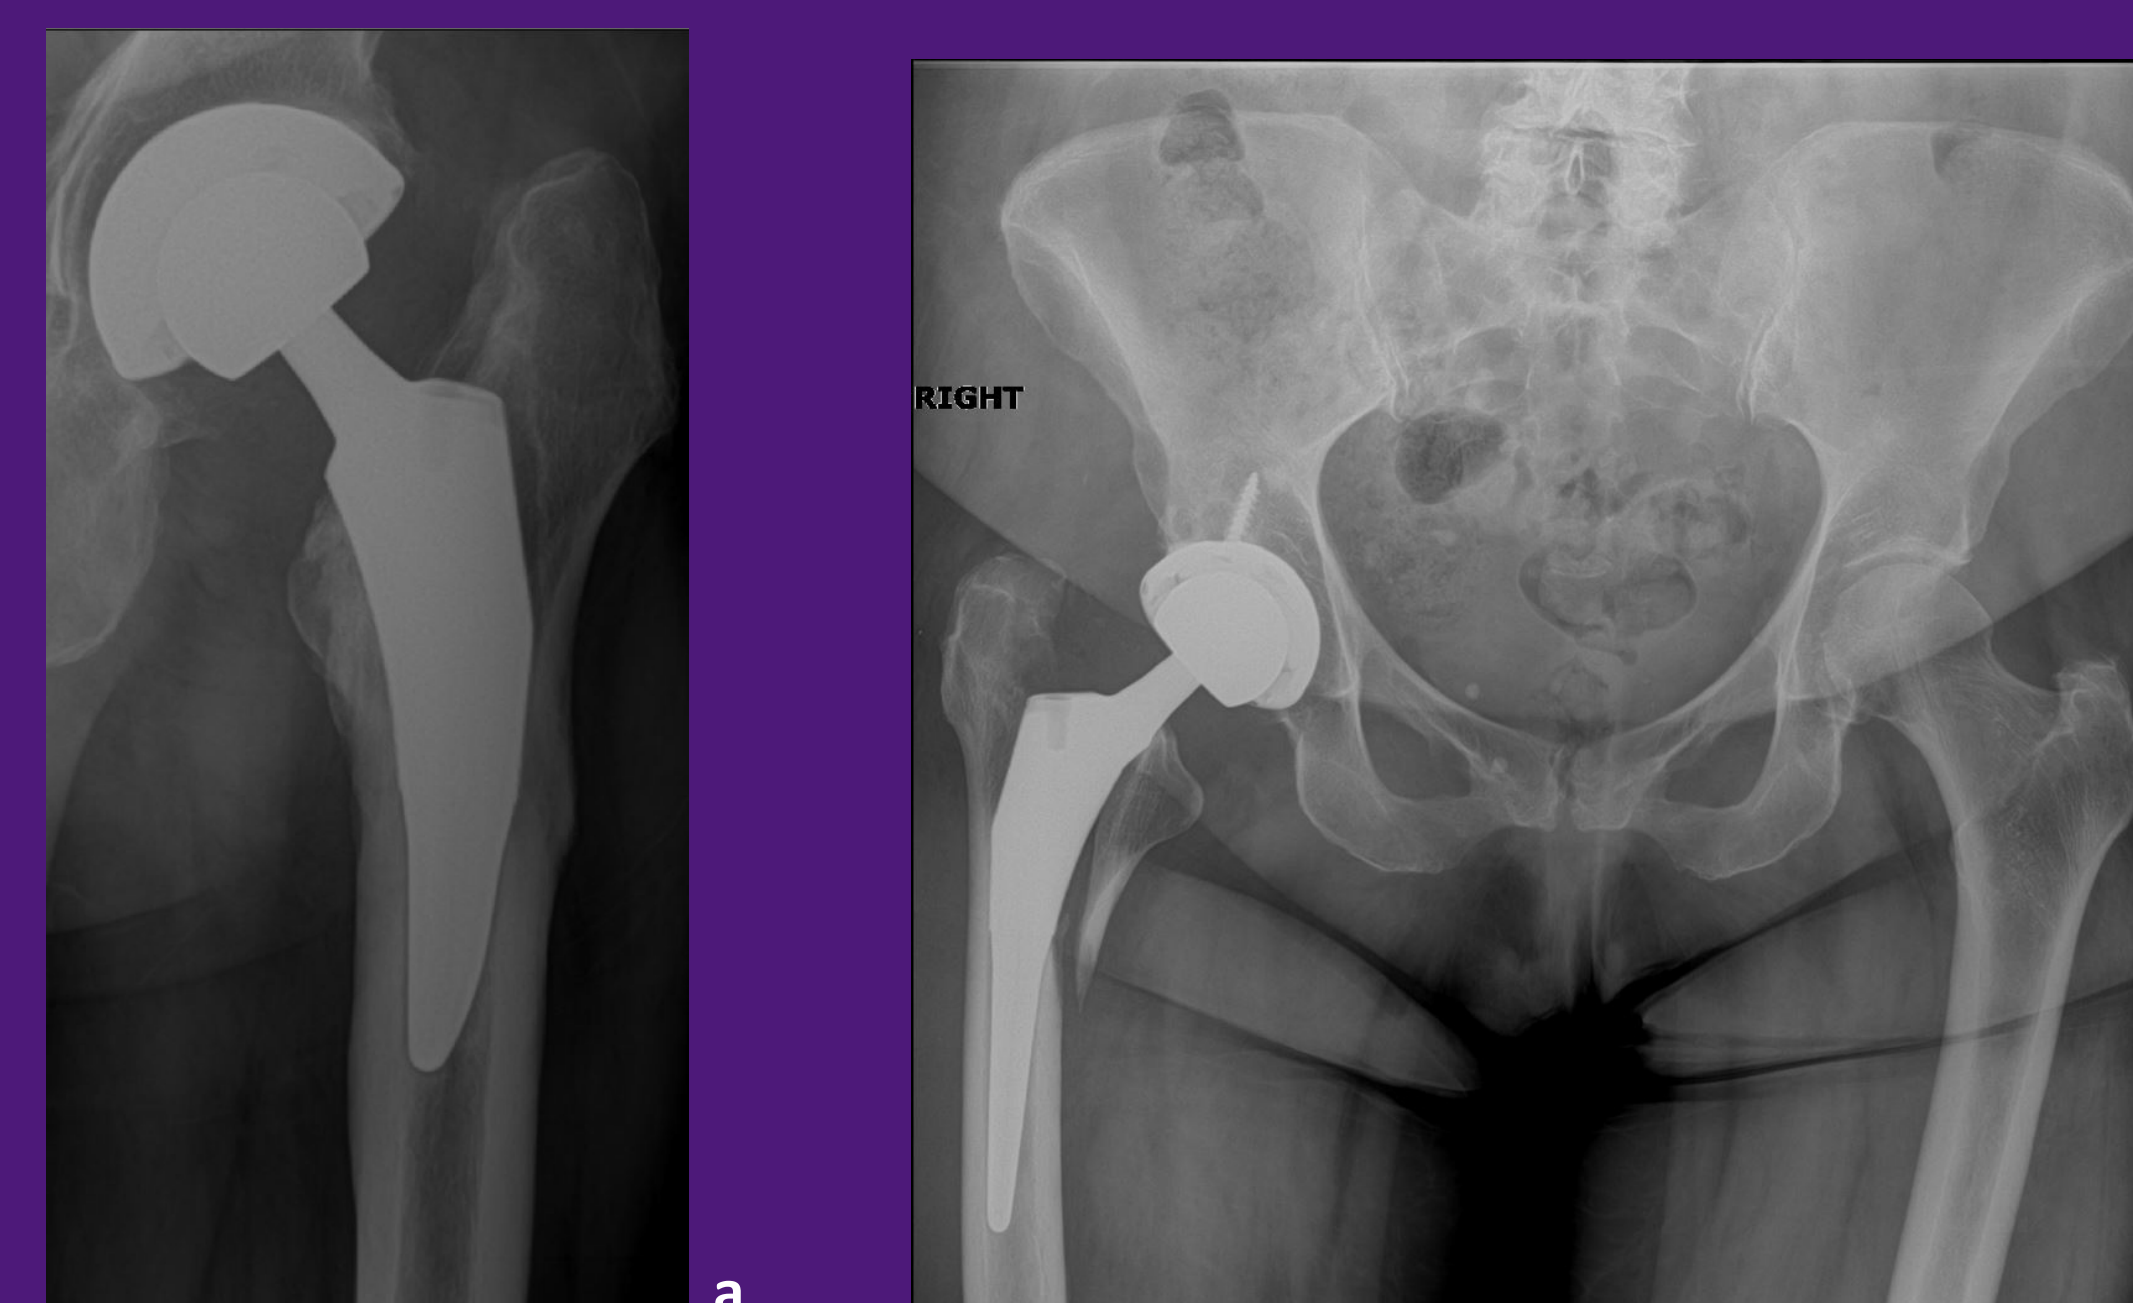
Post-operative Radiographic images showing femoral stem loosening and fracture.
